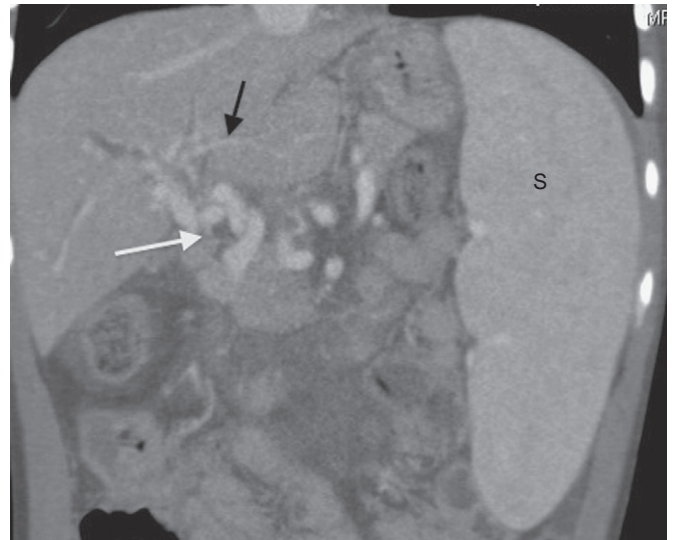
Preoperative computed tomography scan of a child with extrahepatic portal vein thrombosis showing the typical cavernoma, the tangle of varices in the hilum of the liver (white arrow) that replaces the normal portal vein. Also of note is the typically small size of the intrahepatic portal vein branches (black arrow) and the large spleen (S) that appears larger than the liver.
